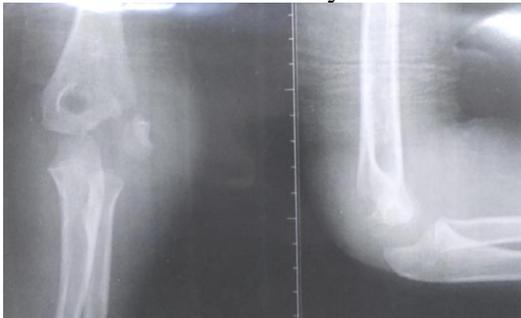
preoperative x-ray of 9 Years old male child with Lateral condyle humerus fr AP view and lateral view
